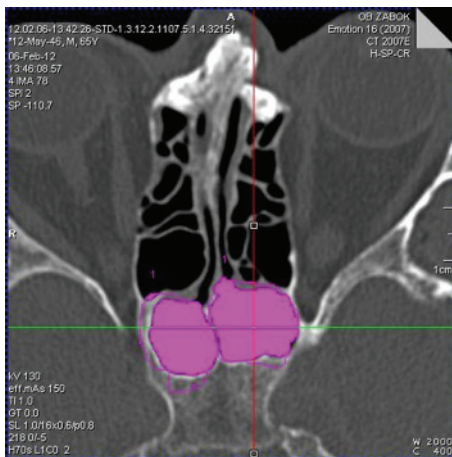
Axial slice of the computed tomography scan of ethmoid sinus.
